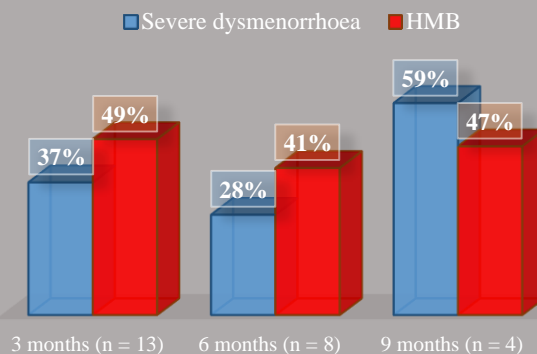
Percentage reduction in symptoms (severe dysmenorrhoea and HMB) severity scores after ultrasound guided-HIFU
